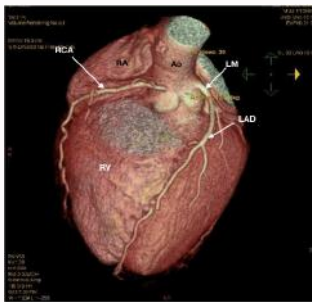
Postoperative CT coronarography after the transfer of the right coronary osmium to the right sinus of Valsalva: CT coronarography (GE 64 slices dual energy, Volume rendering 3D reconstruction, anterior view. RCA: Right Coronary Artery; LM: Left Main; LAD: Left Anterior Descending Artery; RA: Right Atrium; RV: Right Ventricle; AA: Ascending Aorta.
